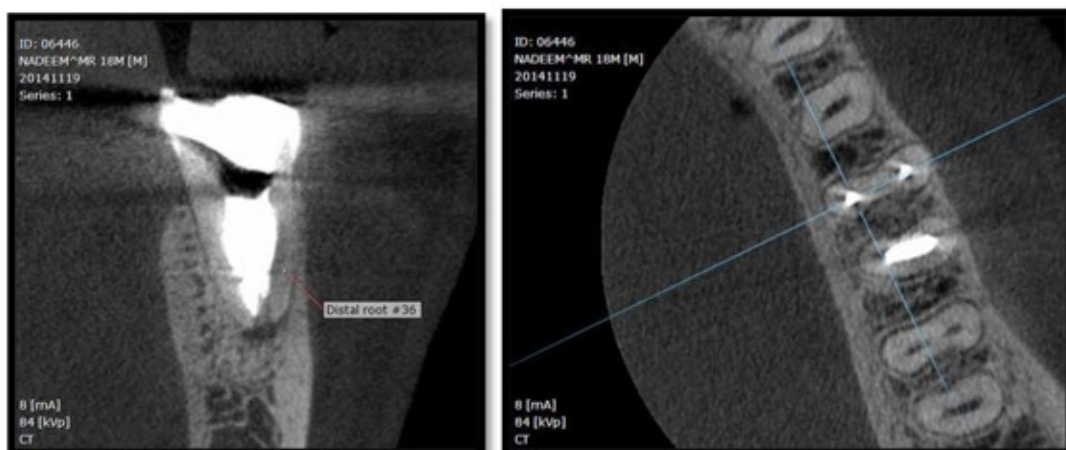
CBCT images of post treatment. Note the density of the filling and the absence of vacuity
